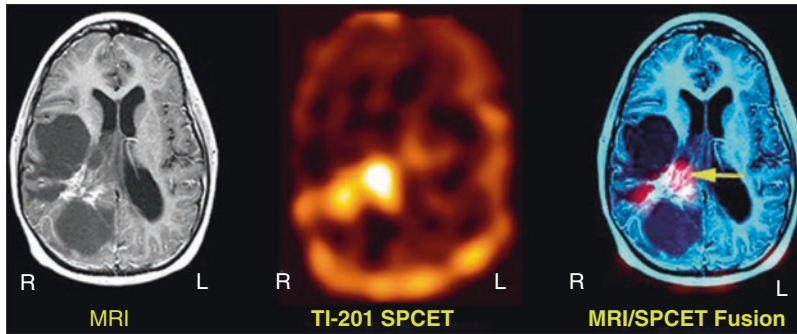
^{201}Tl brain SPECT scan and MR images from a 14-year-old female with recurrent high-grade astrocytoma involving the right hemisphere of the brain. The patient was diagnosed 2 years prior to the scans shown in this figure and underwent two courses of chemotherapy and radiation therapy. The MRI scan (*left*) shows radiation necrosis and cystic lesions, but residual tumor viability cannot be assessed. The ^{201}Tl brain SPECT scan (*middle*) shows a focal region of intense uptake; however, the exact location cannot be determined with certainty. Because this patient was a candidate for gamma knife surgery, it was important to correlate the functional and anatomic image to locate the region of high-grade viable tumor. The MRI–SPECT fusion image (*right*) clearly showed a localized
